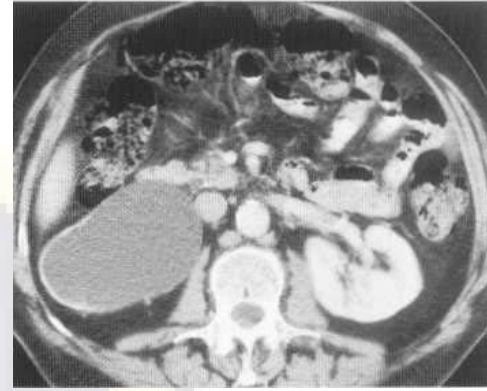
Chronic right pelviureteric junction obstruction with almost complete cortical loss seen on CT.
